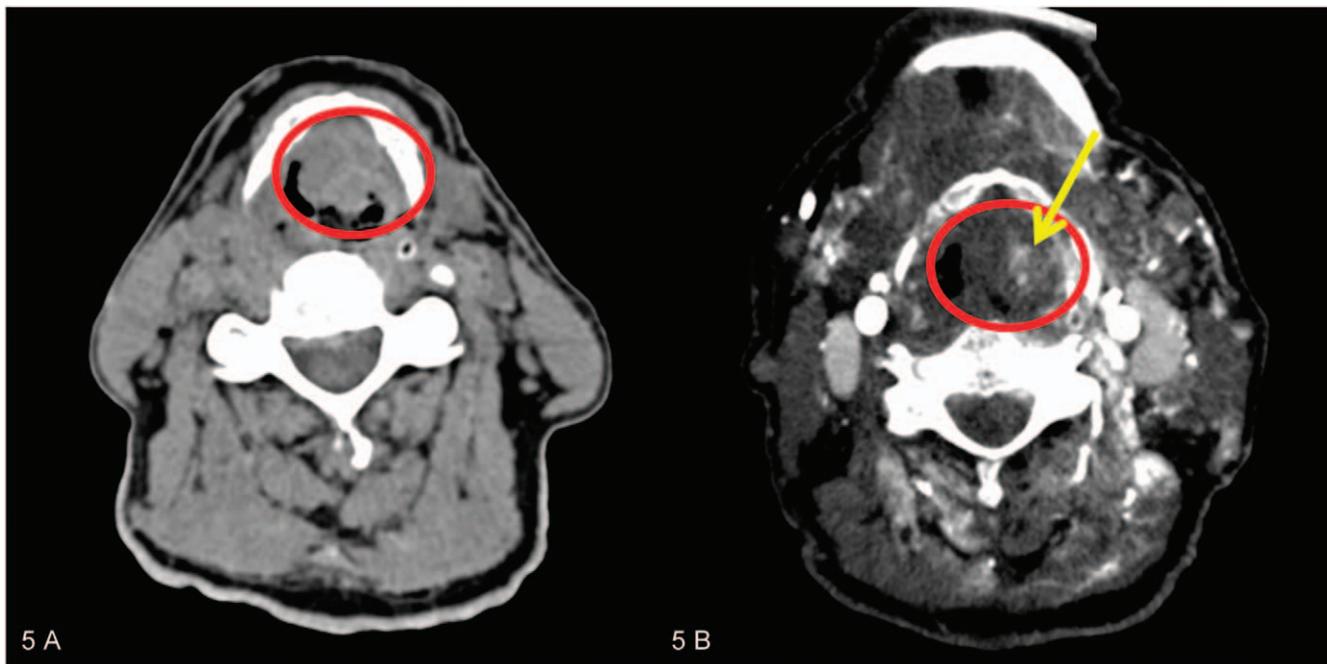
Axial multislice computed tomography cross sections on the neck. Laryngeal masses (red circle). A, Multiplanar reformation of unenhanced multislice computed tomography cross section data. B, Multiplanar reformation of multislice computed tomography cross section data after postmortem angiography. Contrast enhancement of the tumor (yellow arrow).
